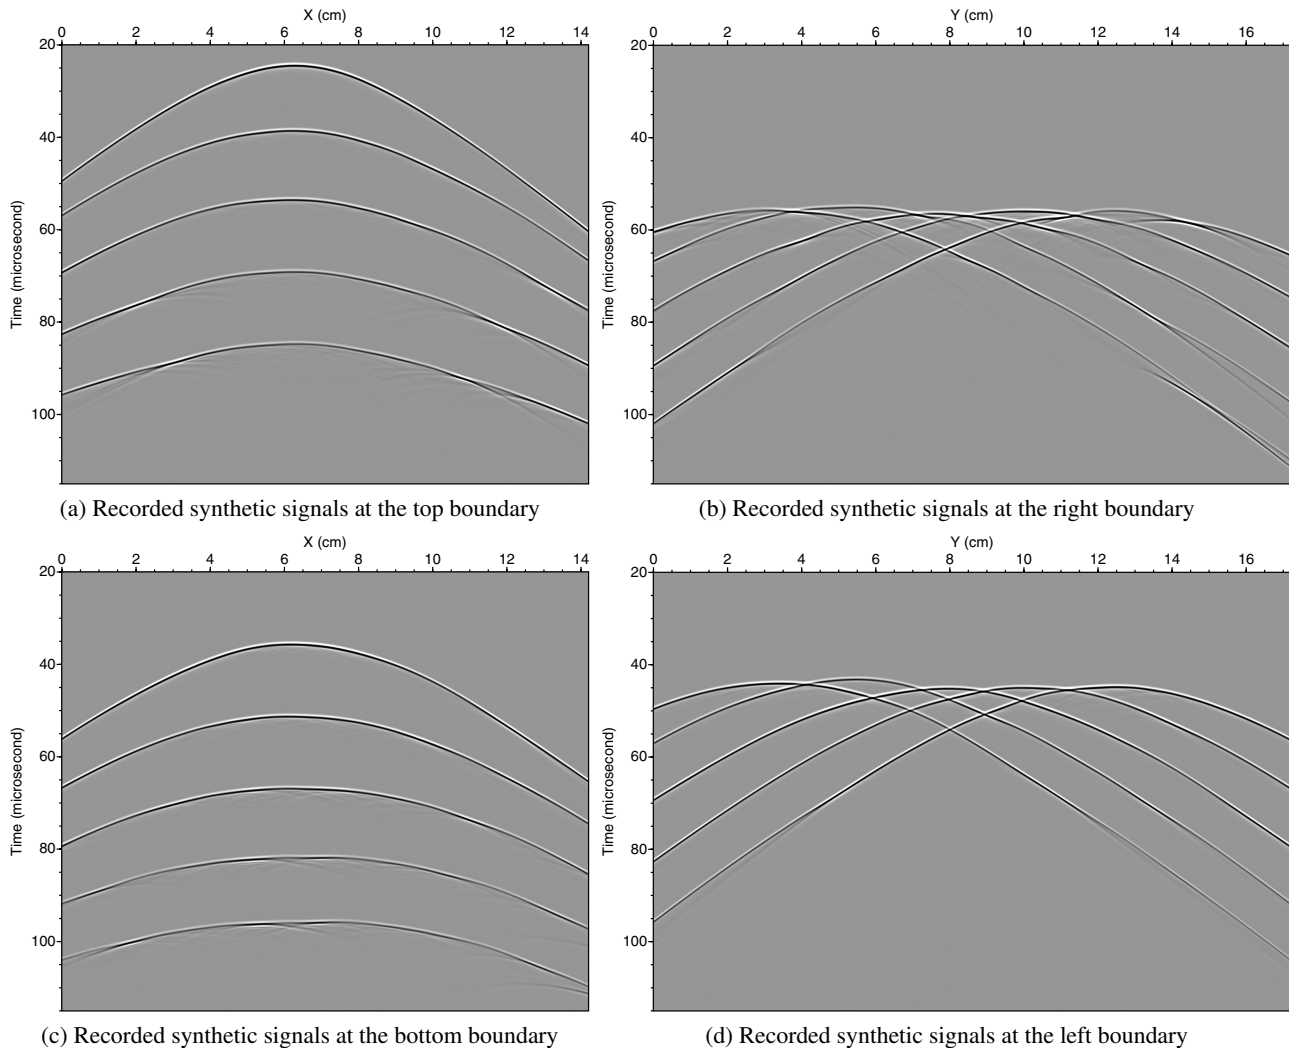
Synthetic ultrasound signals recorded at the top (a), right (b), bottom (c), and left (d) boundaries of the breast model (Figure 1a). They were used to propagating them back to the locations of the five point sources introduced into the breast model in Figure 1(a).
